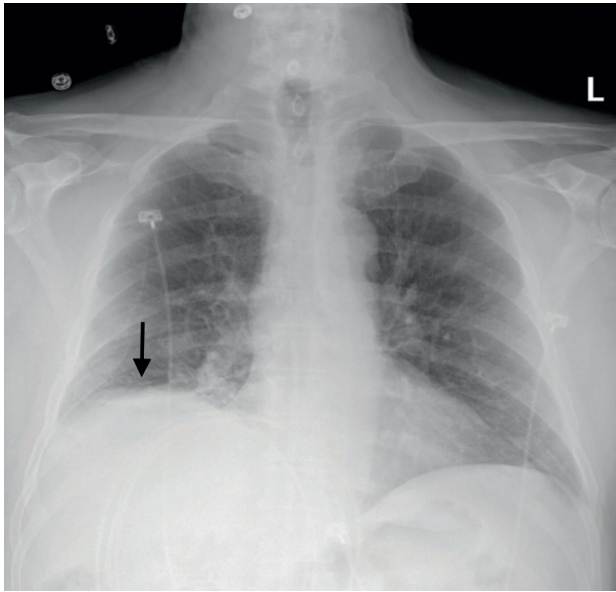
Anterior posterior chest radiograph taken at the institutional-affiliated ED.
